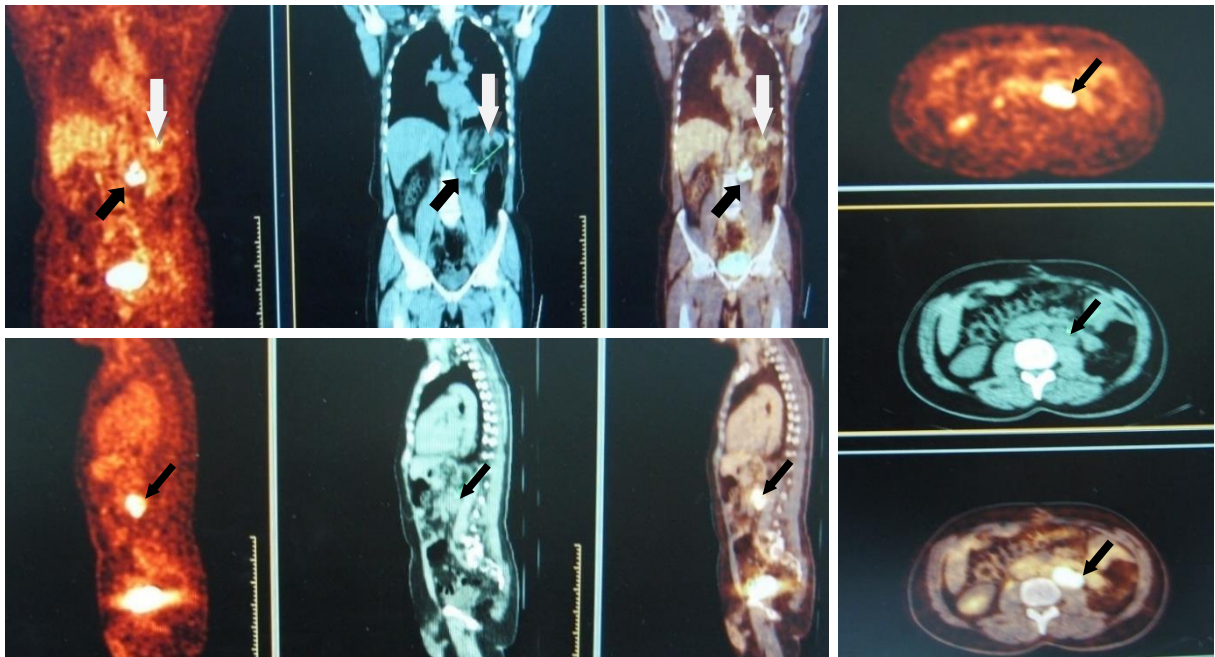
54 year old male with recurrent colonic adenocarcinoma in the splenic flexure. Transaxial, coronal and sagittal images show FDG PET/CT uptake in the operative bed denoting local recurrence (white arrows) and left para-aortic LNs metastases (black arrows). CT findings were false-negative for local recurrence lesion.
